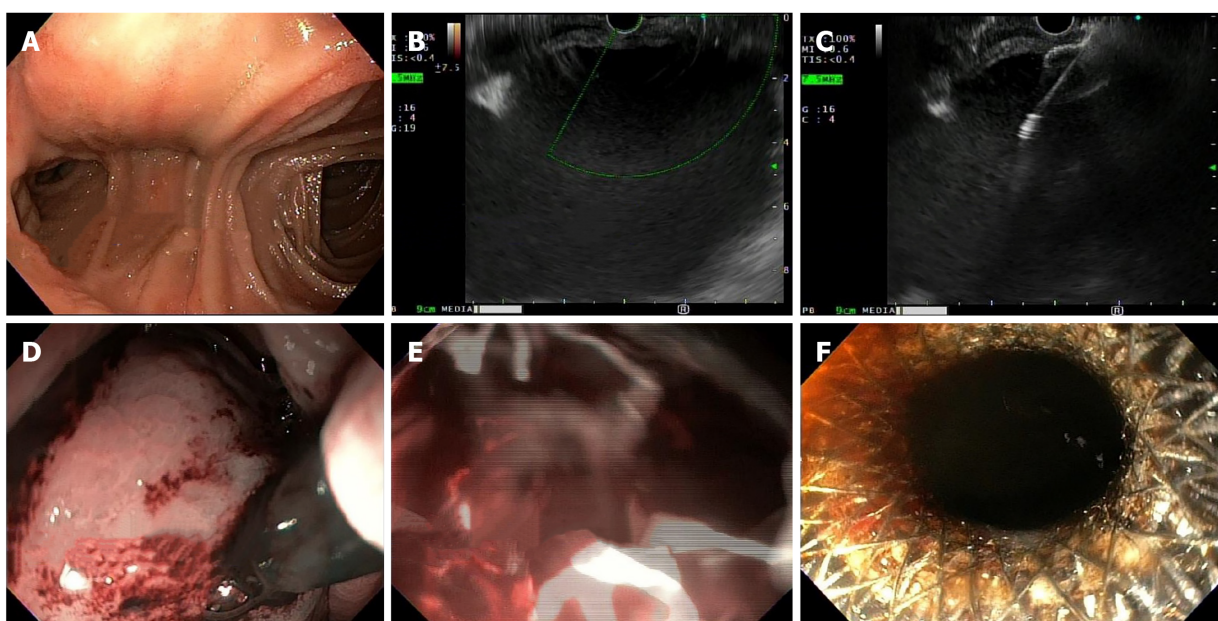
Endoscopy. A: Healthy-appearing mucosa of Roux-en-Y; B: Gastric distension visualized on Endoscopic ultrasound; C: Introduction of Lumen-Appling Metal Stent; D: Endoscopic view of Lumen-Appling Metal Stent placement; E: Immediate decompression with flow of blood through stent; and F: Successful endoscopic ultrasound guided gastro-gastrostomy using Lumen-Appling Metal Stent.
